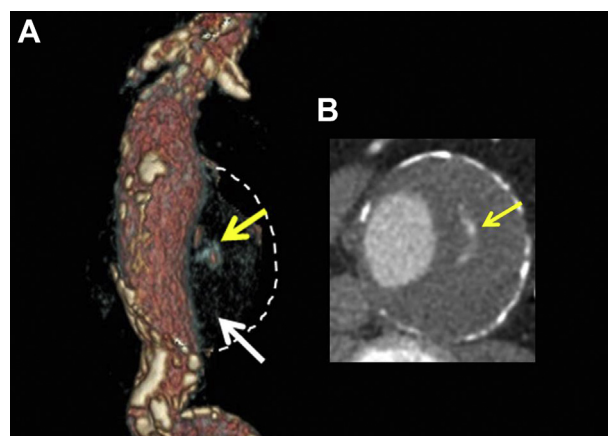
Abdominal aortic aneurysm (AAA) showing active extravasation of contrast (yellow arrow) into thick intraluminal thrombus (ILT; white arrow) that had preceded rupture by 9 days (A) and crescent sign on axial computed tomography angiogram (CTA; yellow arrow; B).
